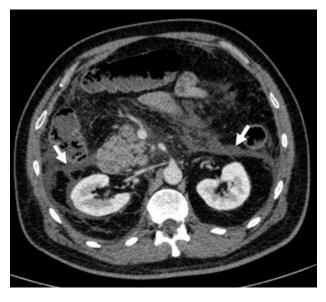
Contrast-enhanced axial abdominal CT images of a 60-year-old man with acute onset of epigastric pain, obtained 48 hours after the onset of pain, reveal that the body and tail (>50%) of the bulky pancreas do not enhance due to necrosis (a).
